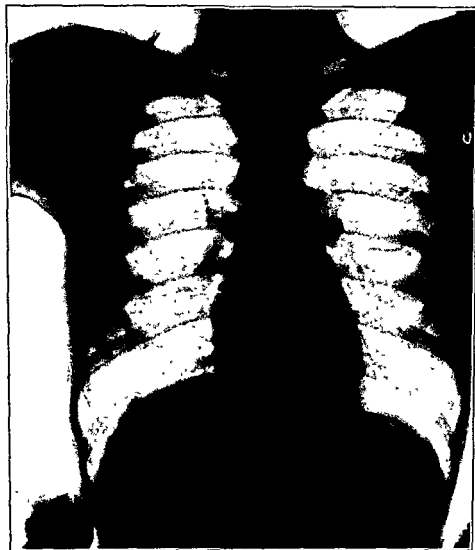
An x-ray of the thorax of Case No. 1 taken sixteen months after the onset of the disease. The tuberculosis has disappeared except for a few fibrotic strands in the right lower lobe.
